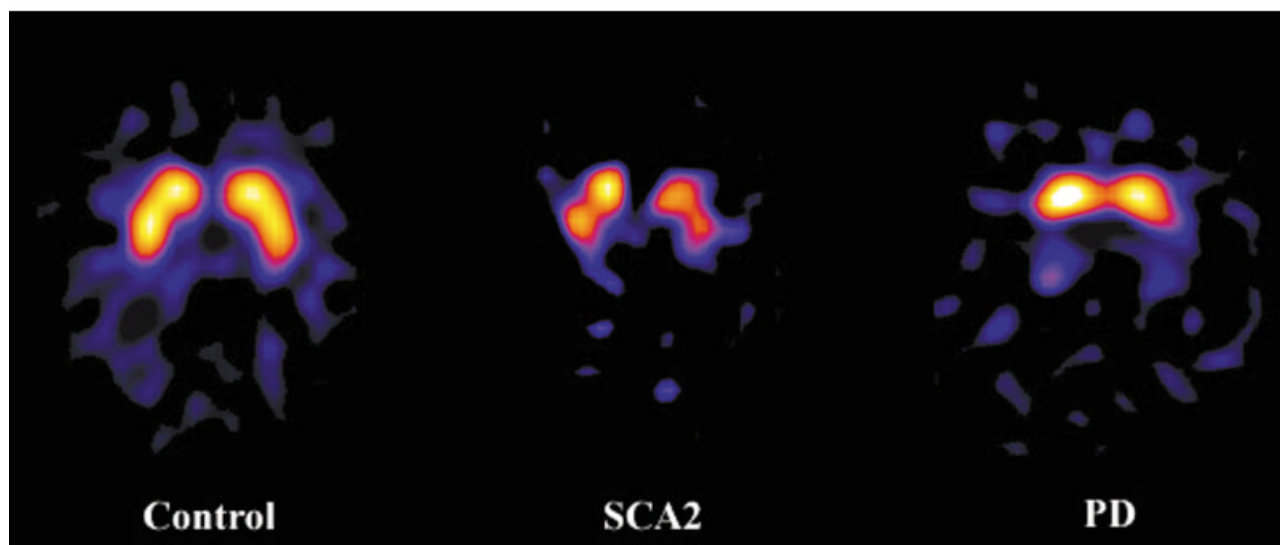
Transaxial [^{123}I]FP-CIT single-photon emission computed tomography scans at the level of basal ganglia in a control (left), a SCA2 patient (middle), and a Parkinson's disease patient (right). [^{123}I]FP-CIT binding was markedly reduced in both patients and showed a more uniform reduction in SCA2.
